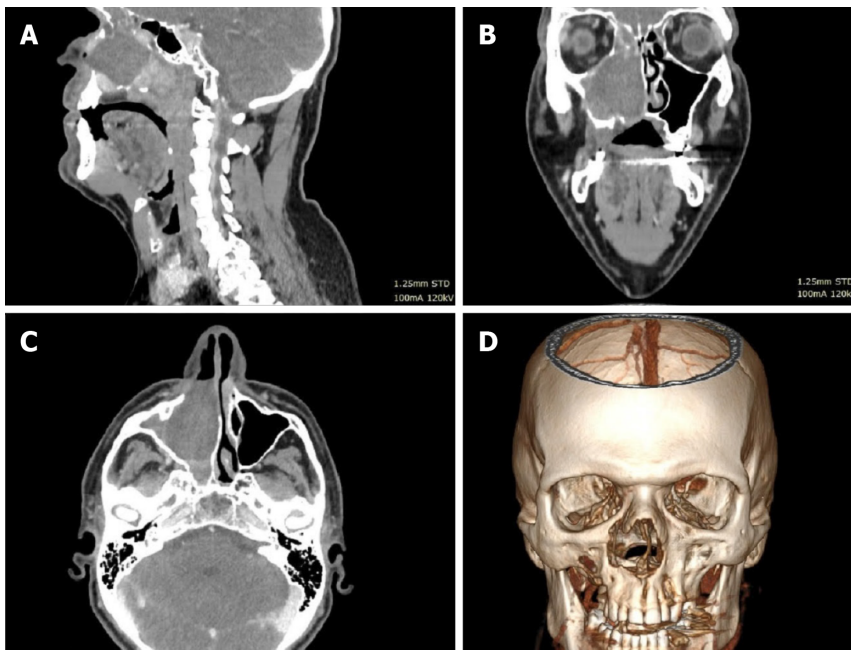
Case 1 computed tomography scan with contrast and 3D reconstruction. Solid contrast-enhancing tumor filling the maxillary sinus and eroding the bony plate is shown. A: Sagittal section; B: Coronal section; C: Axial section; D: 3D reconstruction.
